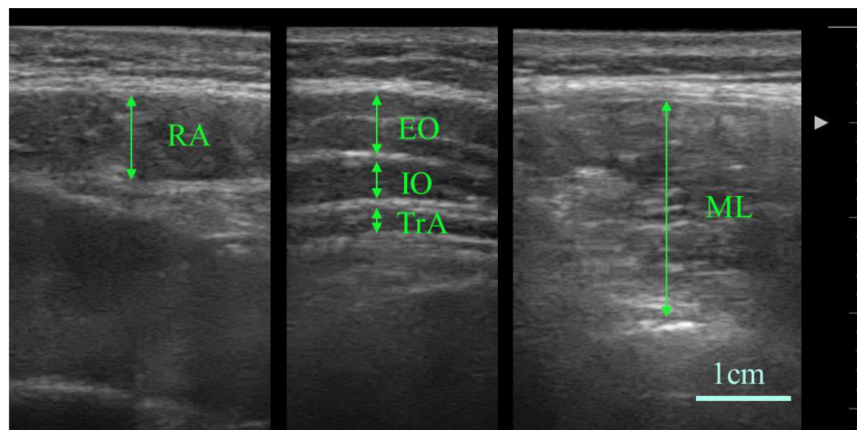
Measurement of muscle thickness using ultrasonography. RA: Rectus abdominis, EO: External oblique, IO: Internal oblique, TrA: Transverse abdominis, ML: Multifidus lumborum.
